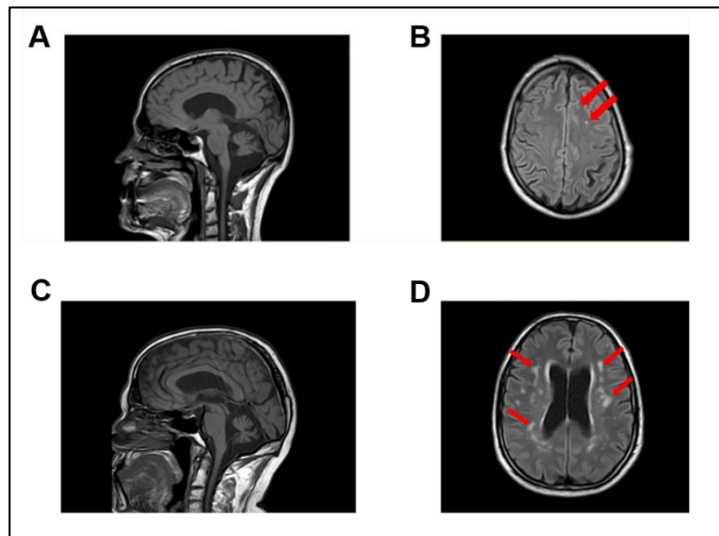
Sagittal and transverse magnetic resonance imaging scans revealed cerebellar atrophy and cerebral diffuse demyelination. Sagittal and transverse T1-weighted magnetic resonance imaging scans of patient V:1 brain revealed cerebellar atrophy (A) and initial signs of brain demyelination lesions (B) noted by red arrows. Imaging of the brain of patient's IV:1 father (IV:2) also showed cerebellar vermis atrophy (C) and marked cerebral diffuse demyelination (D) noted by red arrows.
